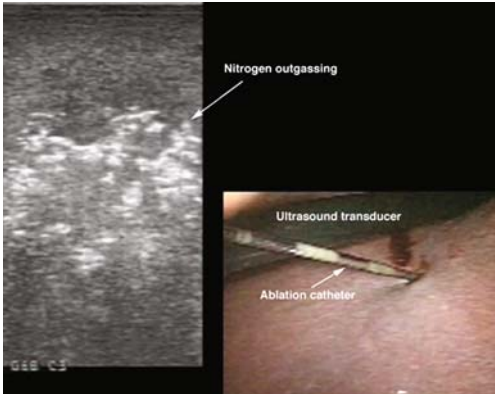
Ultrasound view of nitrogen outgassing during ablation cycle.
